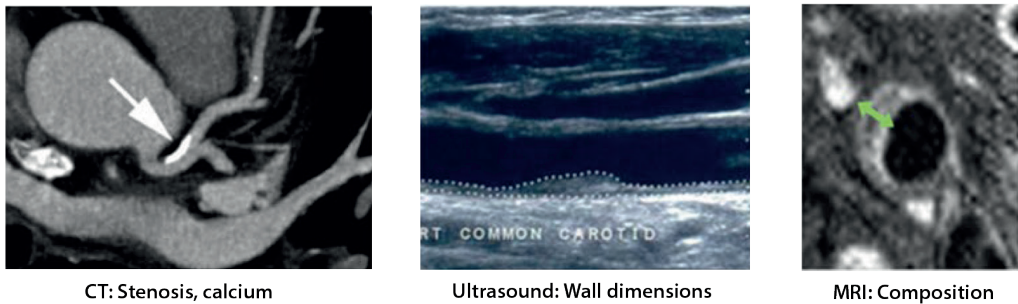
Shows traditional imaging methods used for plaque visualization. CT angiography and ultrasound give information on luminal narrowing or calcification (calcification indicated by white arrow). MR imaging can give information on plaque composition, but often lacks the resolution required to give this information for small plaques, especially in the coronary arteries. From (7).
